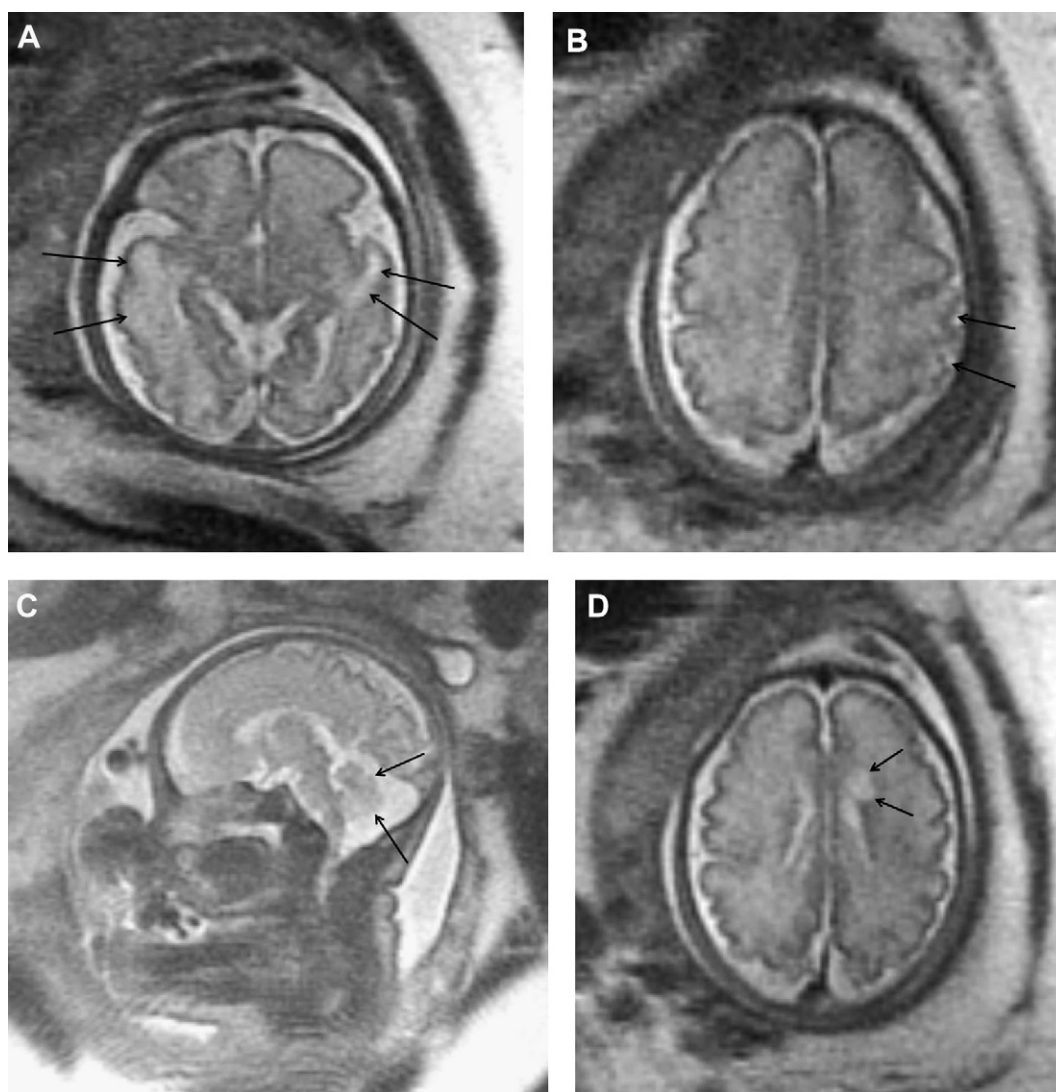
Fetal ultrafast magnetic resonance imaging at 32 weeks of gestation shows (A) hypomyelination with increased T2 signal intensity over bilateral temporal white matter (arrows); (B) pachygyria with effacement of cortical gyri (arrows); (C) cerebellar atrophy (arrows); and (D) a cyst arising from the frontal horn of left lateral ventricle (arrows).
